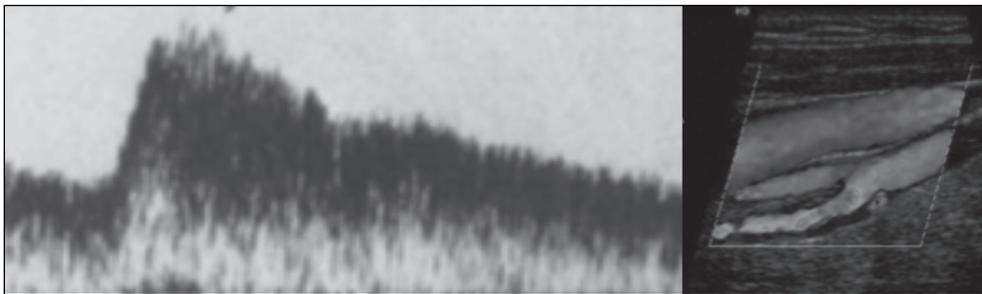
Doppler ultrasound. Doppler spectral analysis, when introduced in the 70s, was largely performed by vascular surgeons. The development of color Doppler in 1983 introduced many radiologists to Doppler, now an integral part of the ultrasound exam.
